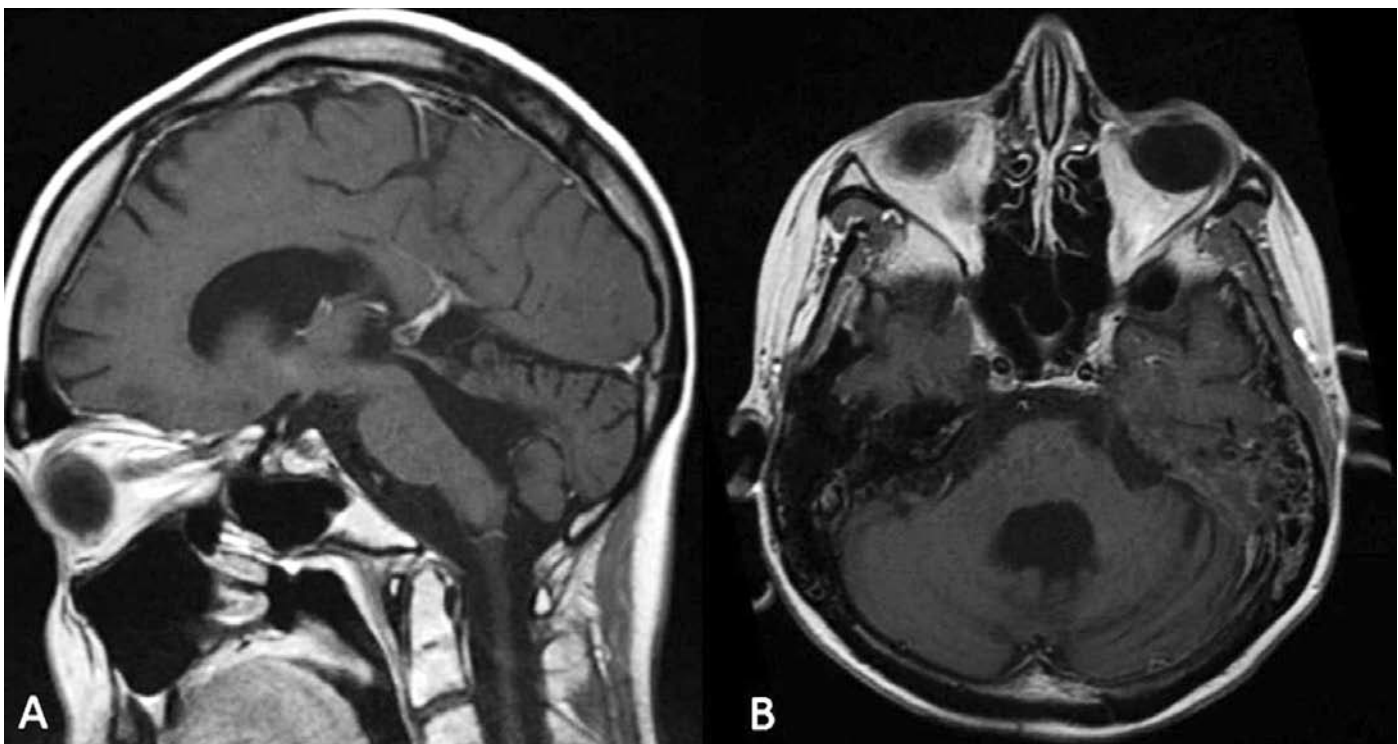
Sagittal (A) and axial (B) MRI control scan 30 months after the operation without any residuum
